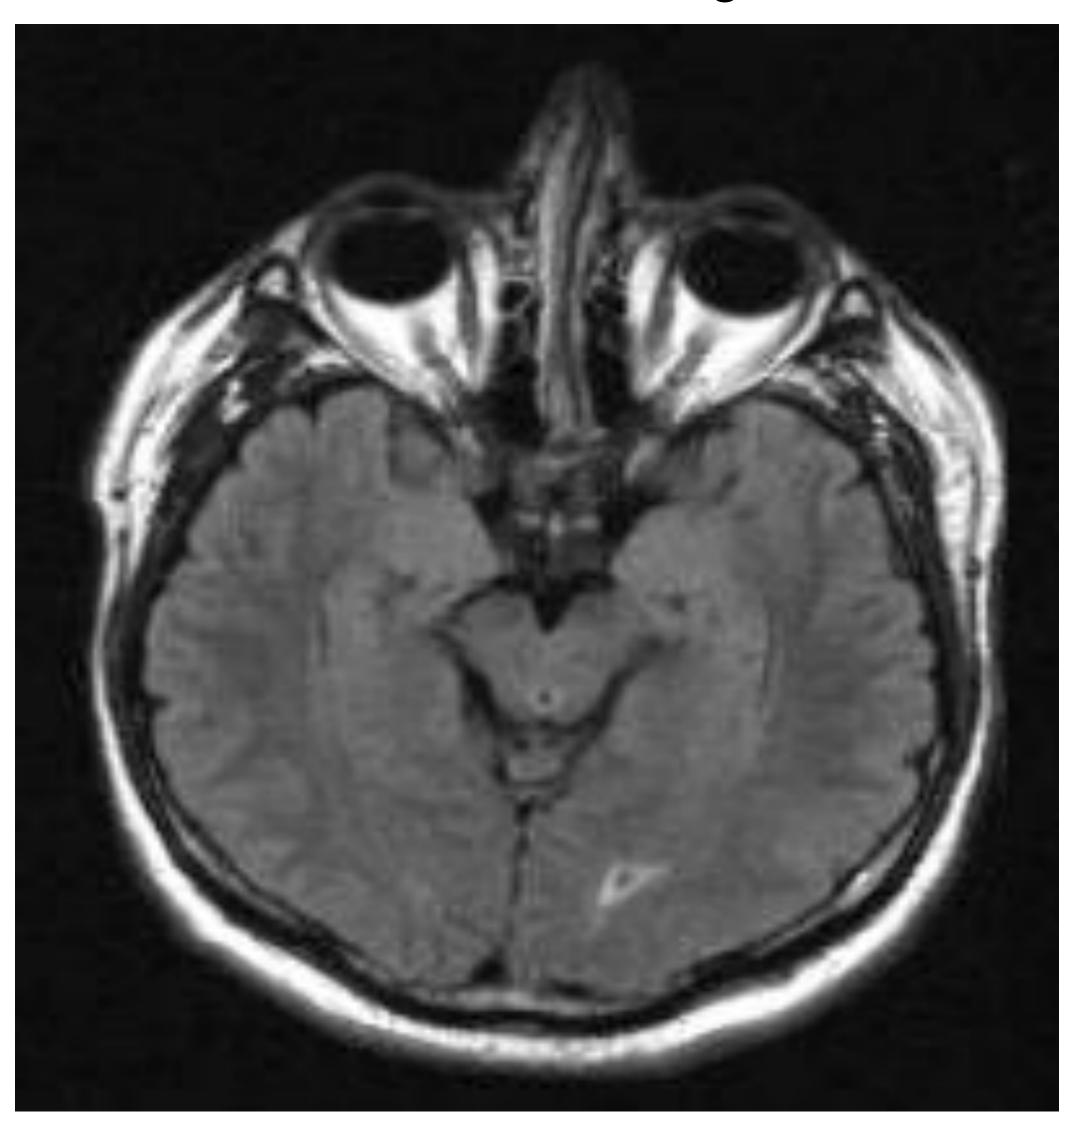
MRI of the brain shows age-appropriate cortical atrophy with no acute intracranial findings.
